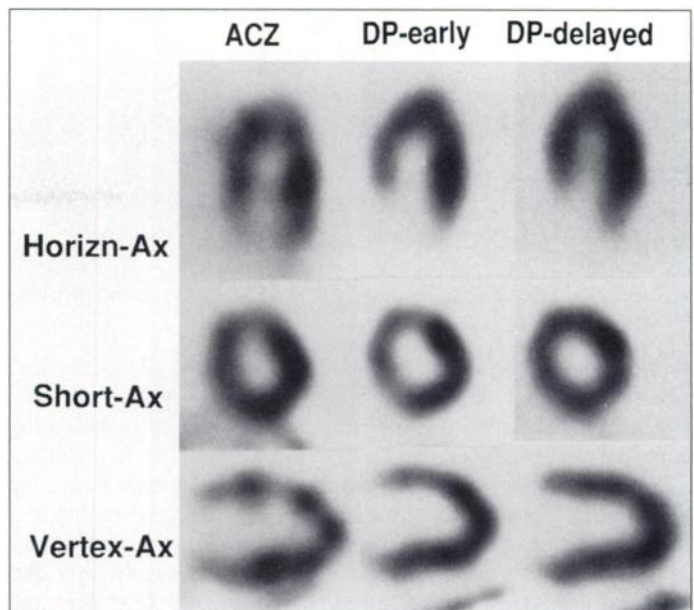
Thallium-201 myocardial SPECT with ACZ shows a defect in anterior and septal walls (left row). Thallium-201 myocardial SPECT with dipyridamole also reveals a defect in anteroapical and septal walls in the early images and redistribution in the delayed images (middle and right rows).
